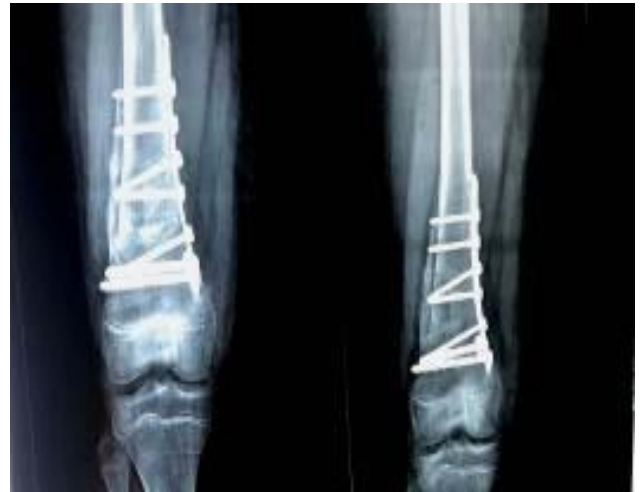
Standing radiographs AP views were taken at 6 months show callus formation and completely healing at site of osteotomy cut.
